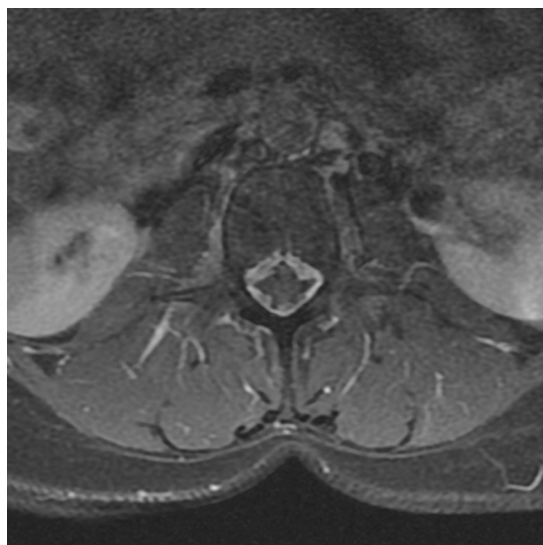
MRI of the lumbar spine. T1-weighted axial section with fat saturation (TR/TE: 761/9.208) after intravenous injection of gadolinium.
